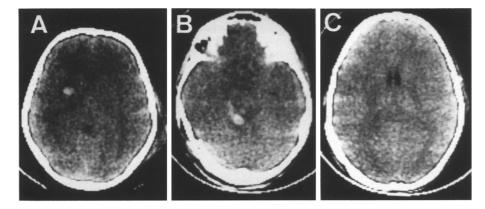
A Admission CT scan of a patient who made a good recovery after suffering an acute head injury. An intraparenchymal clot at the left basal ganglia is present. B, C Correspond to an admission CT scan of a patient who entered the hospital with bilateral mydriasis and died after 3 days
